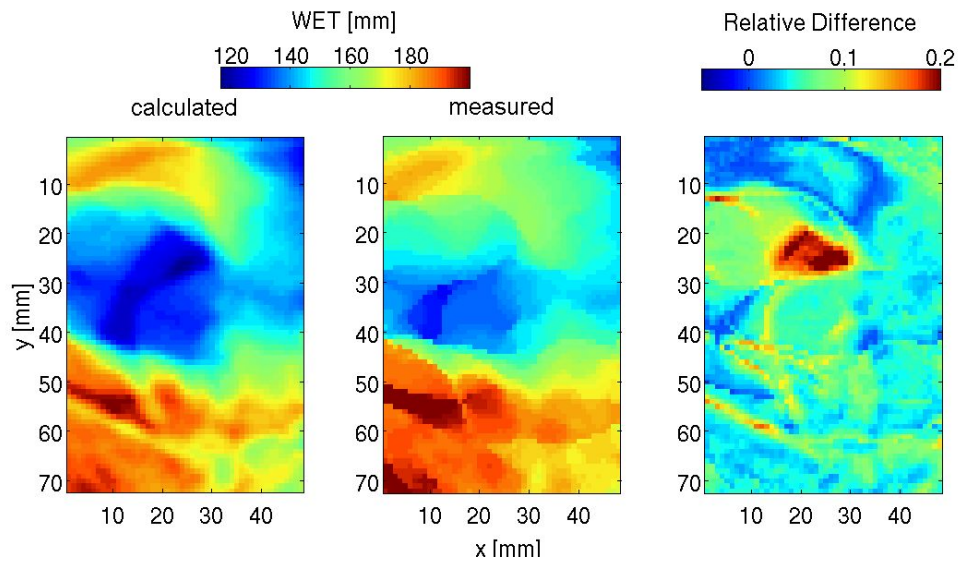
Region 1: Left: WET map calculated from CT data. Middle: Measured WET distribution with carbon ions. Right: Relative difference between the calculated and measured WET distribution.
